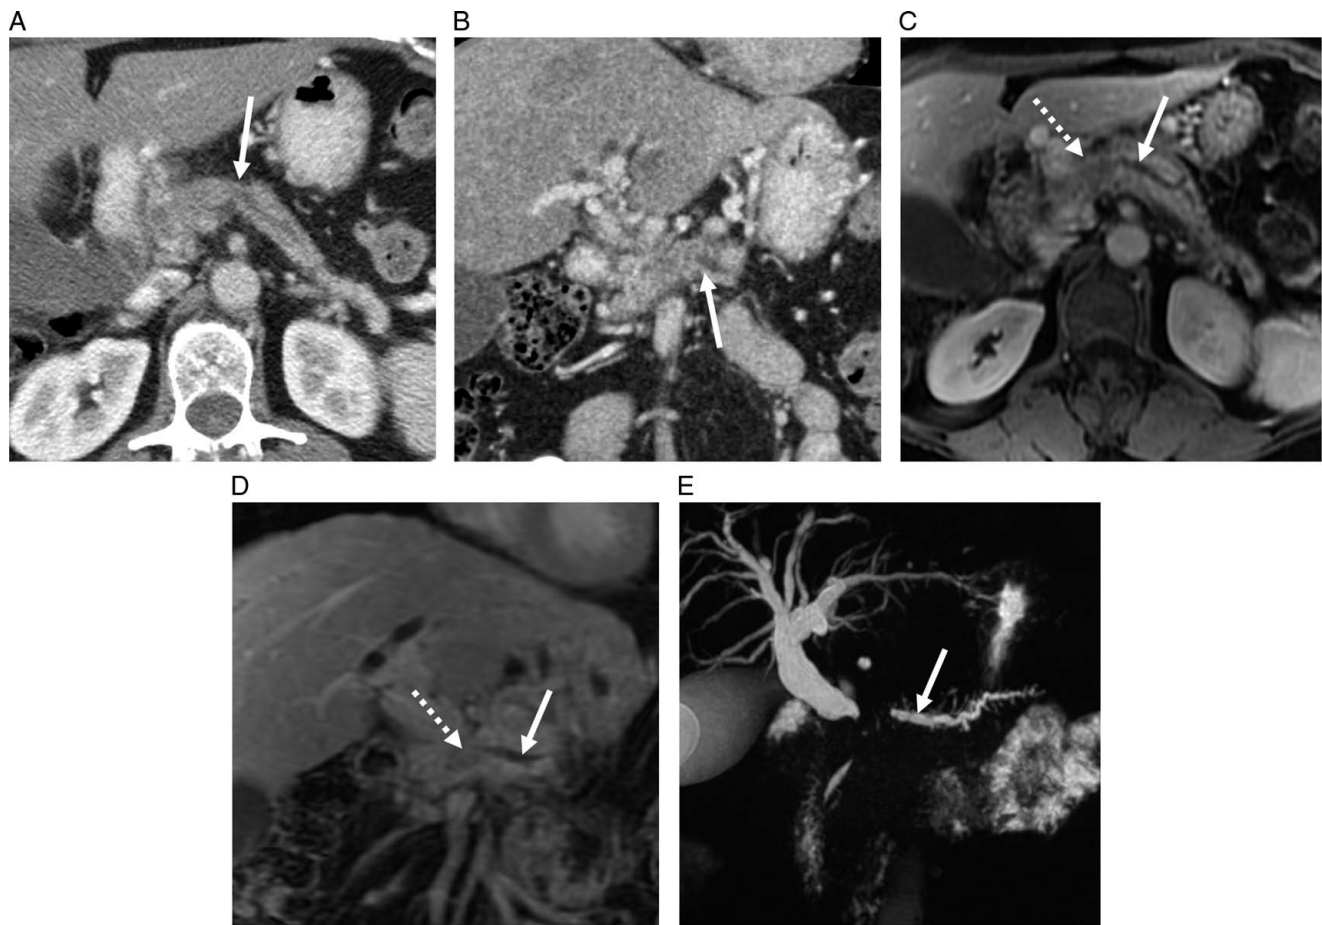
A 55-year-old woman who presented with lower abdominal pain. Axial (A) and coronal (B) intravenous (i.v.) contrast-enhanced computed tomography (CT) images in the portal venous phase obtained at outside institutions did not report any pancreatic abnormality. In retrospect, there was mild dilatation of the pancreatic duct (arrow) without discrete pancreatic mass. Two-month follow-up axial (C) and coronal (D) i.v. contrast-enhanced T1-weighted MR (magnetic resonance) images showed subtle hypoenhancing mass (dotted arrows) as the cause for the pancreatic duct dilatation (arrows). Coronal magnetic resonance cholangiopancreatography image (E) showed an abrupt cut-off of the dilated pancreatic duct, an important secondary sign in the diagnosis of PDAC (pancreatic ductal adenocarcinoma).
